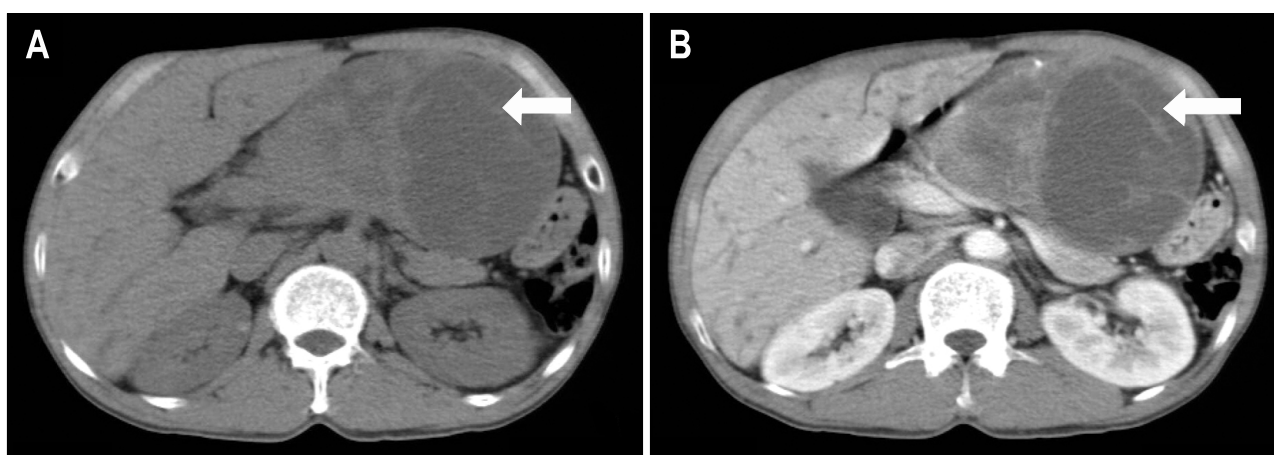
Abdominal CT findings. (A) Non-contrast abdominal CT showed a heterogenous mass like lesion (white arrow). (B) Contrast abdominal CT showed a well-defined heterogeneous enhancing mass, about 10 cm in size between the left hepatic lobe and the lesser curvature side of the gastric body (white arrow).
